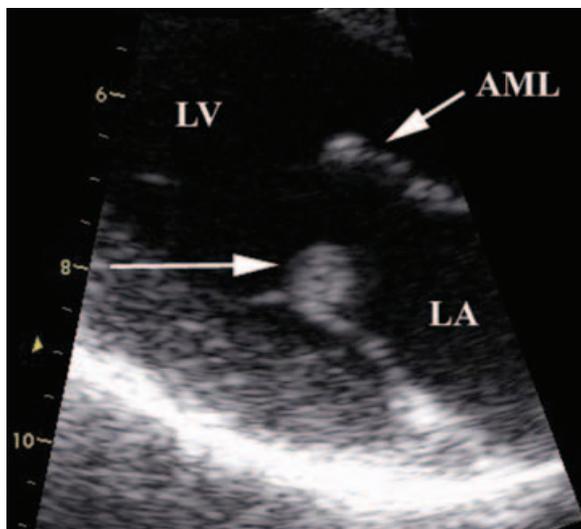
Diastolic parasternal long-axis image demonstrates a 1-cm rounded mass (horizontal arrow) attached to the tip of the posterior leaflet of the mitral valve. AML = anterior mitral leaflet; LA = left atrium; LV = left ventricle.
